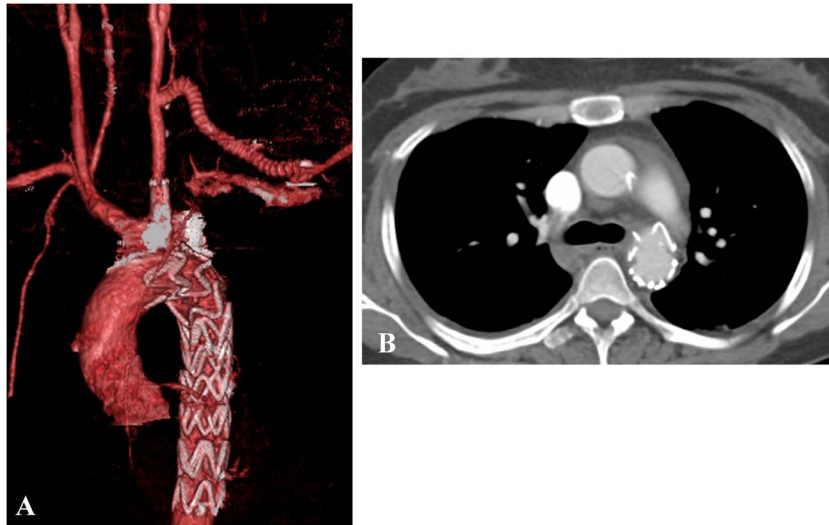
Computed tomography (CT) angiography after surgery. A: Three-dimensional-CT. B: Axial image.
